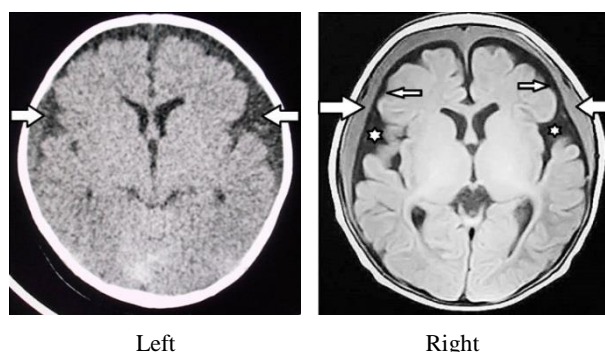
Case 4 (No. 13), male aged 2 months. Left: CT on arrival demonstrating bilateral, extra-axial fluid collections (arrows). Right: MRI (FLAIR, axial view) demonstrating bilateral ASDHy (arrows). Note the BESS (small arrows) and LSF (stars). No mass effect or intraparenchymal abnormality was observed on the other sequences (not shown).
